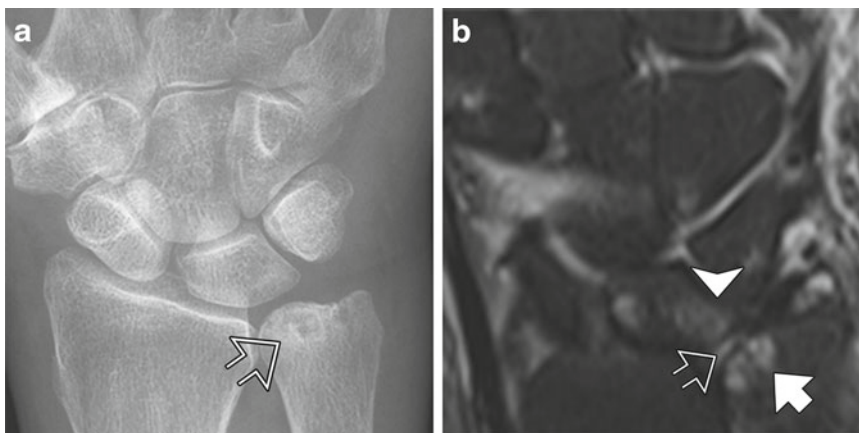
Ulnar-carpal impaction syndrome, advanced stage (a) Radiograph shows positive ulnar variance with cystic changes in the distal ulna (arrow). (b) Coronal STIR MR image reveals cystic change in the distal ulna (solid arrow) as well as chondral loss. There is a large
